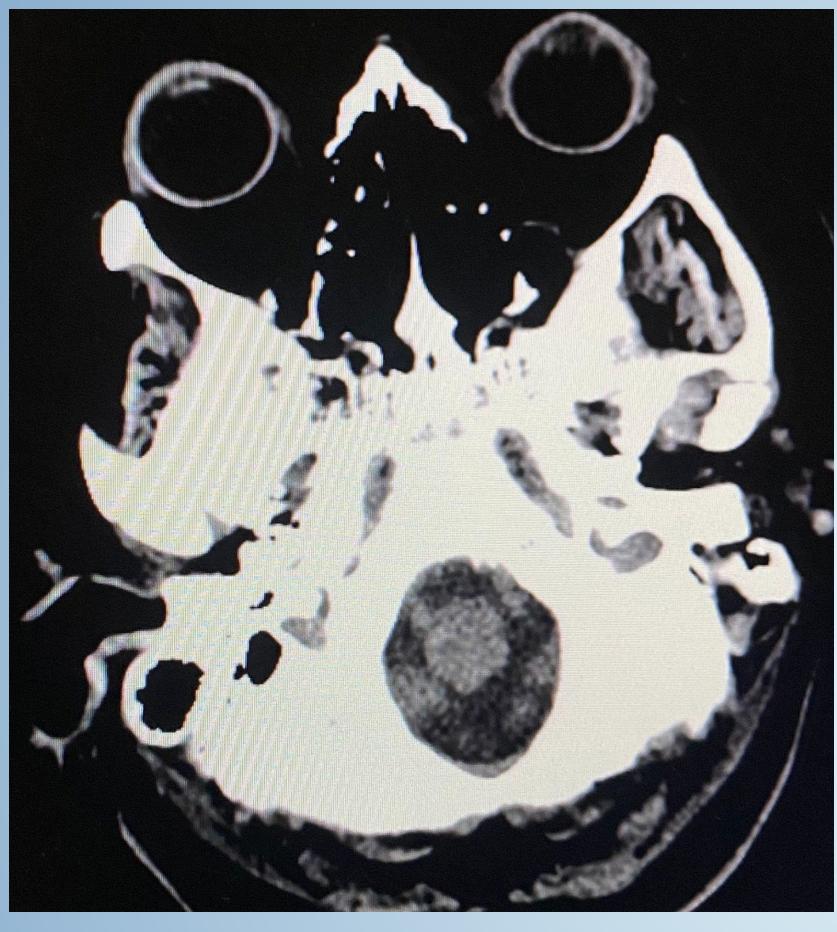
A CT scan of the head after onset of neurological symptoms demonstrating no intraocular hemorrhage.
